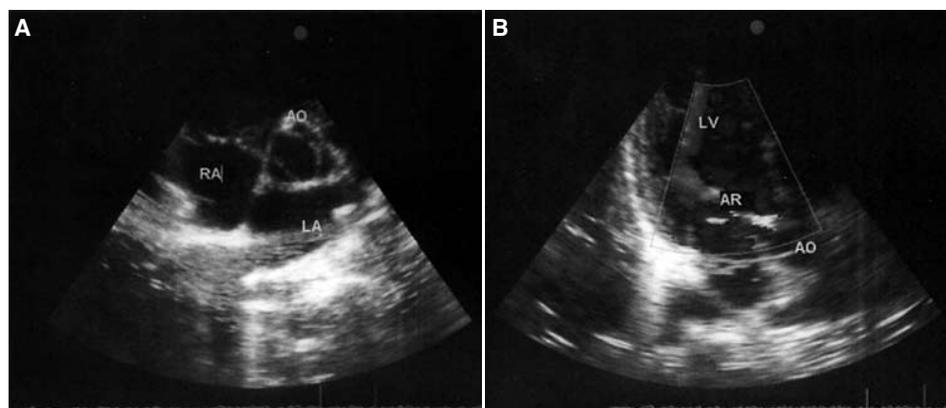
Images of (A) bicuspid aortic valve in the parasternal short-axis view and (B) aortic regurgitation in the apical view.
